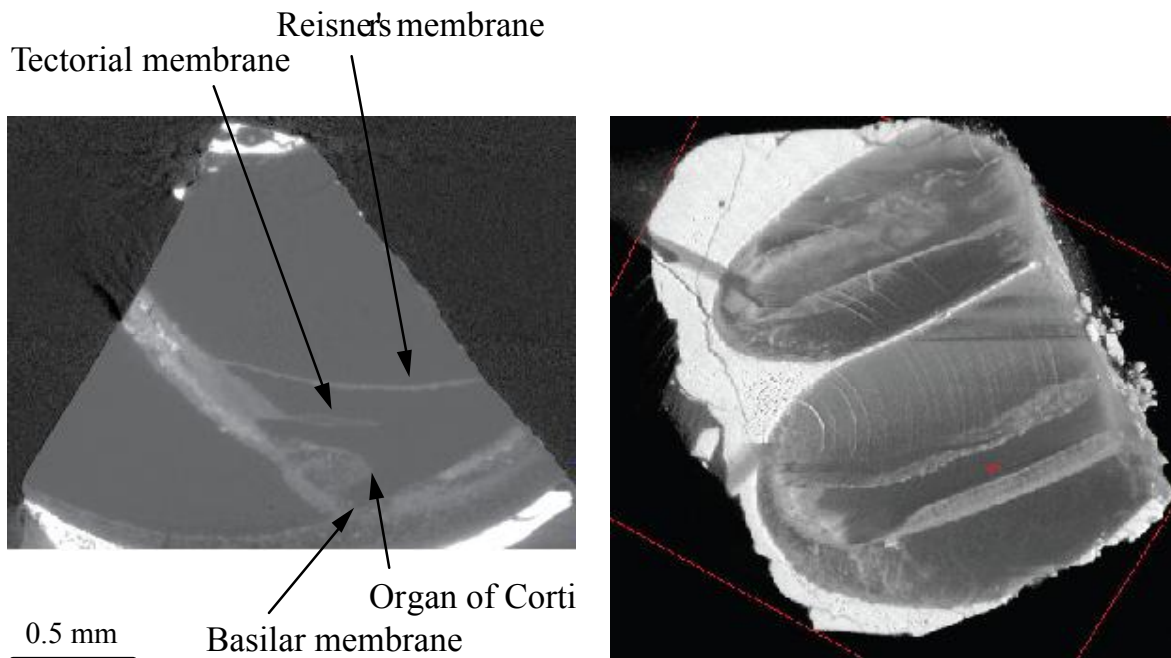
The slice on the left demonstrates the power of SR μ CT uncovering cellular anatomic features inside the cochlea including the Reissner's membrane, the tectorial membrane, the basilar membrane as well as the organ of Corti. The 3D representation on the right shows the membranes in the middle and apical turn on coarser scale. Inside the two turns one sees the cochlear duct, which is filled with endolymph and defined by the Reissner's membrane on the upper side and the basilar membrane on the lower one.
